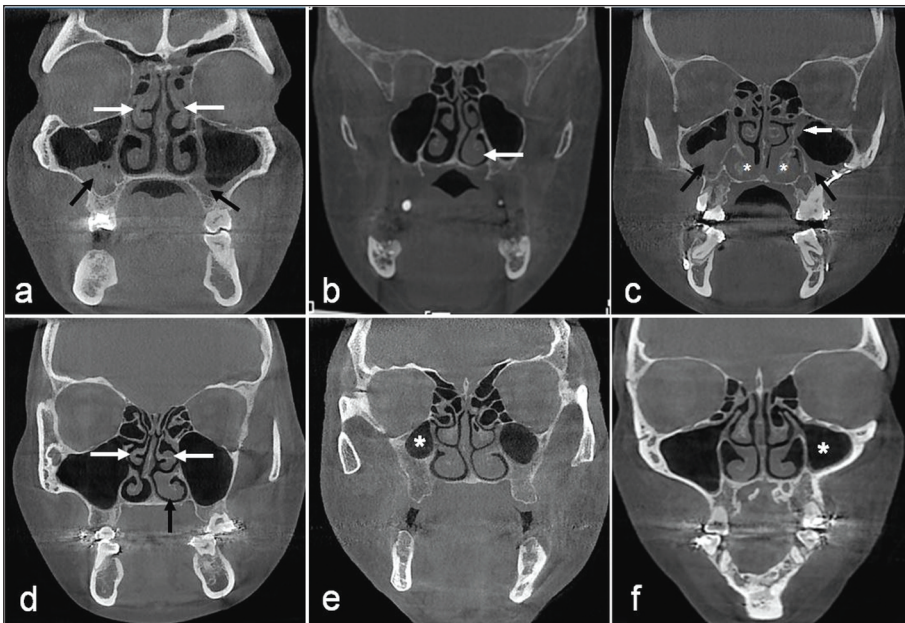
The coronal CBCT scans of some of the variations. a) Bilateral PMC (white arrows) and mucosal thickening of the maxillary sinuses (black arrows) in a patient with normal maxilla position; b) NSD and left ICH (arrow) in a patient with maxillary prognathia; c) ICH (asterisks) with together bilaterally mucosal thickening of maxillary sinuses (black arrows) and the obstruction of MSO (white arrow) in a patient with maxillary retrognathia; d) Bilateral PMC (white arrows) and left ICH (black arrow) in a patient with maxillary retrognathia; e) The hypoplasia of right maxillary sinus (asterisk) in a patient with normal maxilla position; f) The hypoplasia of left maxillary sinus (asterisk) in a patient with maxillary retrognathia.
